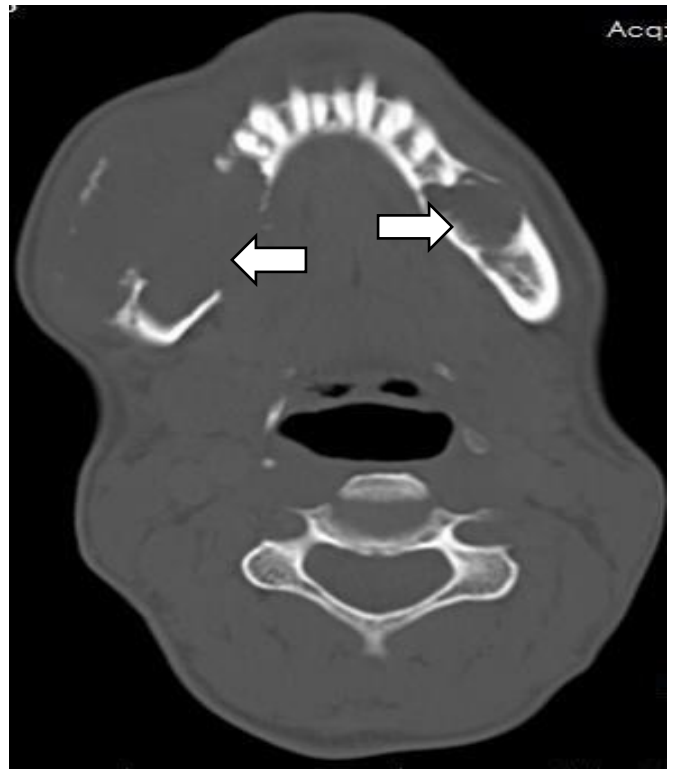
Axial CT scan of mandible showing destructive lesion (bone window)
